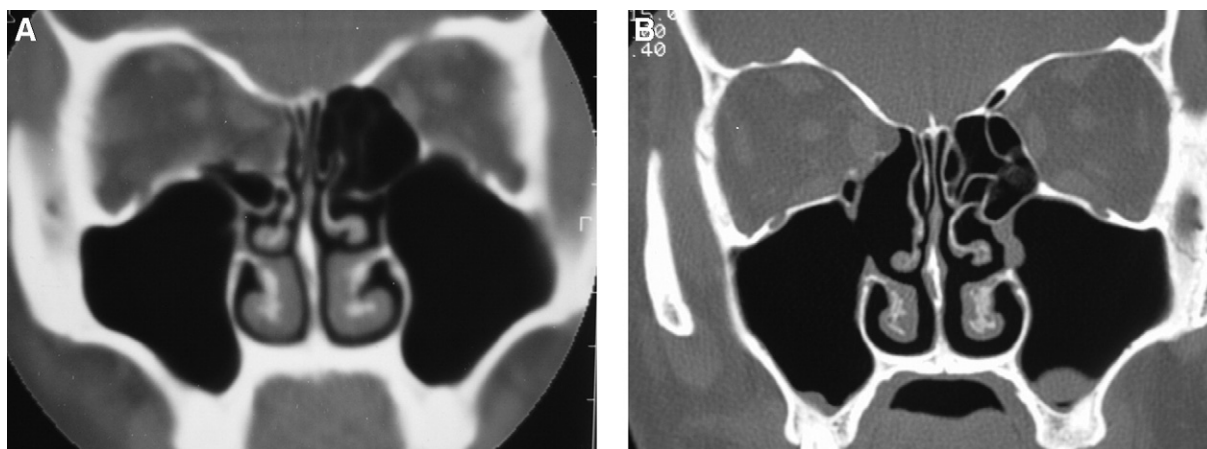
(A) Preoperative CT scan shows a large blowout fracture of the right medial orbital wall with herniation of orbital tissue. (B) CT scan taken at 8 weeks after surgery shows a well-reduced medial orbital wall.
